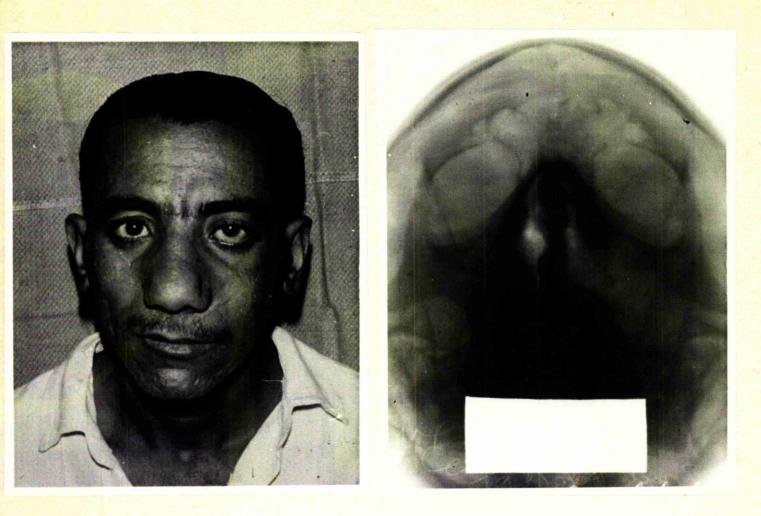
CASE NO. 3. Showing prominence of the left cheek. Fig. 9b. Xray showing destruction of the left antral walls.
